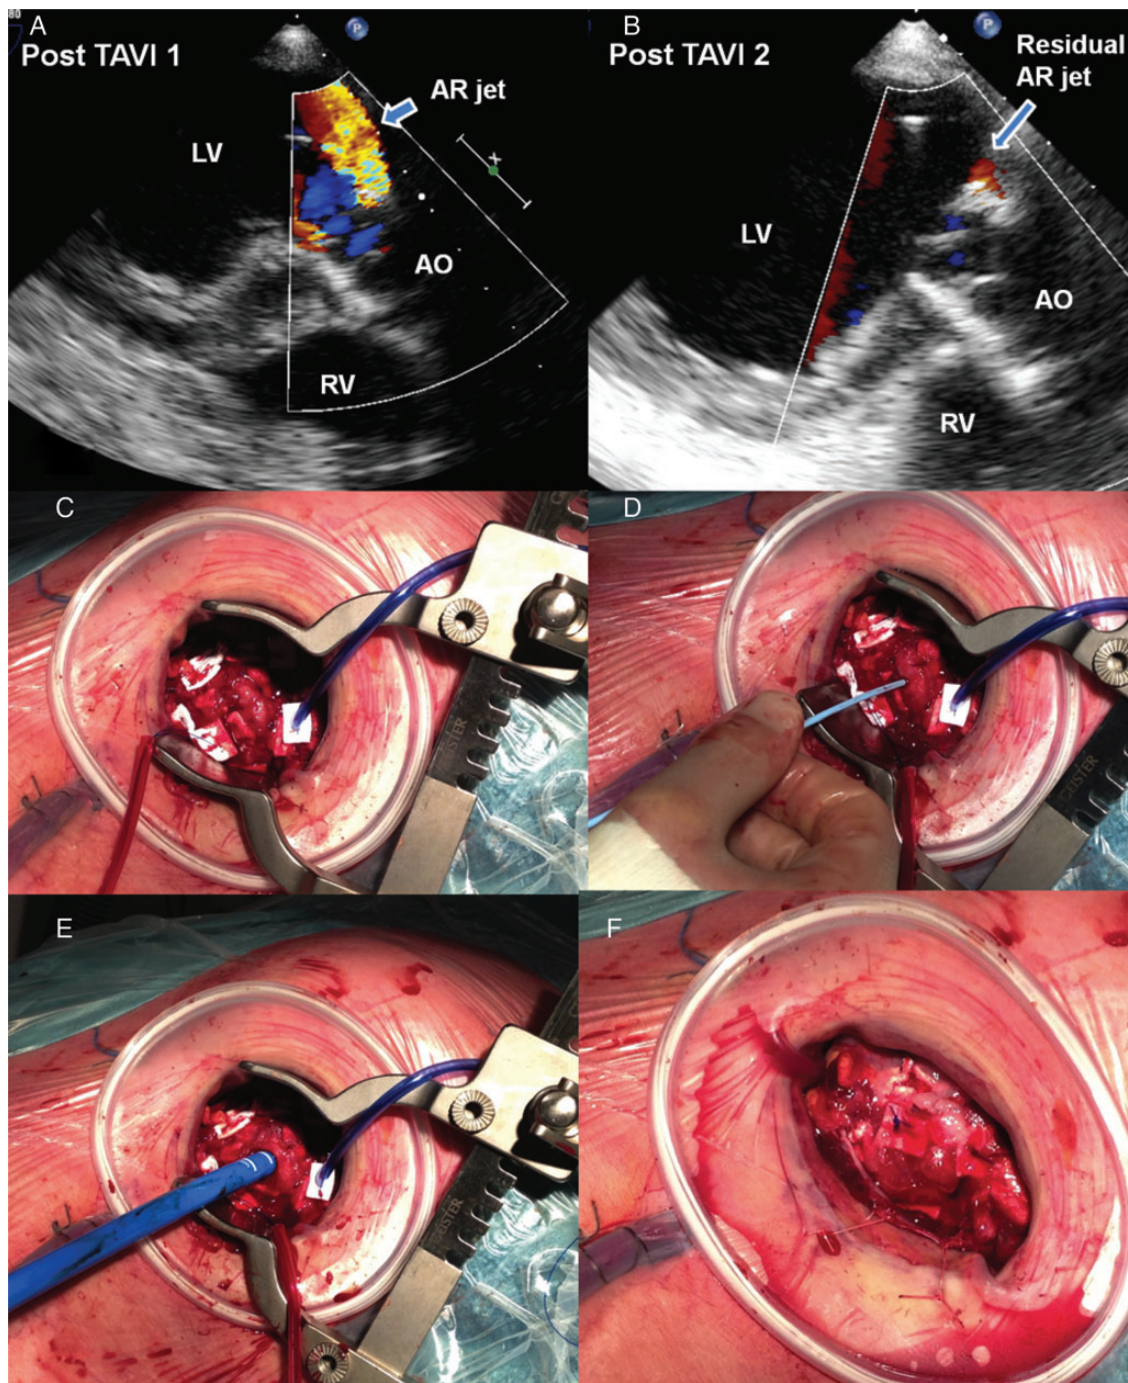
(A and B) Echocardiographic views of the paravalvular leak after the first TA-TAVI (A) and after the redo TA-TAVI (B) (intra-gastric LVOT views: 130°. LV: left ventricle, RV: right ventricle, AO: aorta); (C, D and E) the surgical field with the insertion of the guidewire, the pigtail and the delivery system; (F) the final result.
